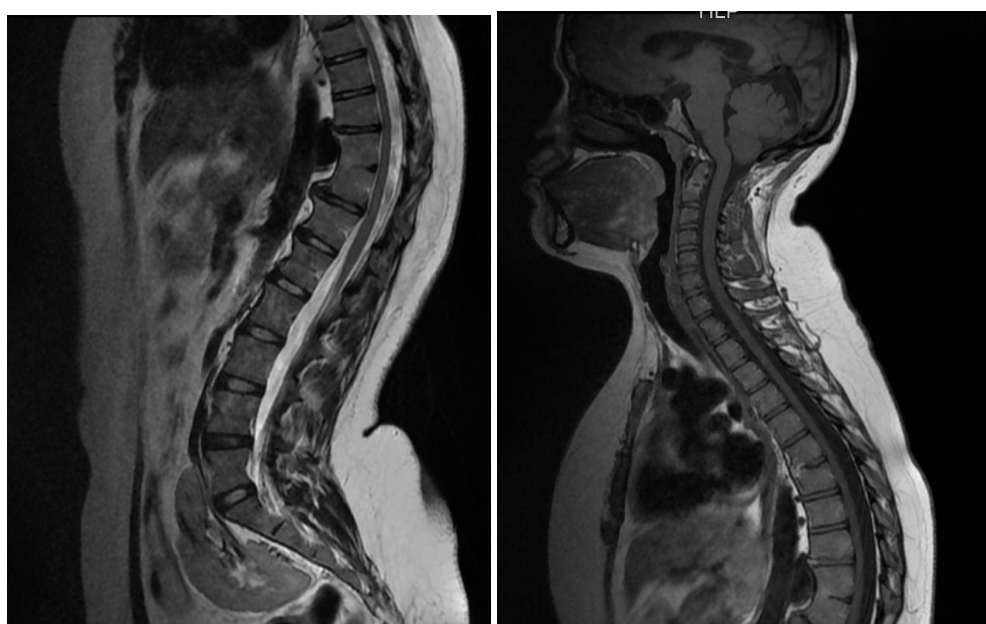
Spinal cord MRI: T2 sagittal slices: exaggeration of dorsolumbar curvatures with vertebral blocks D6-D7 and D10-D11
